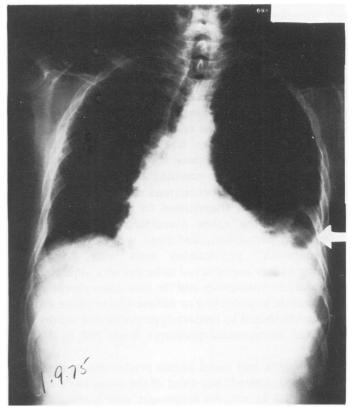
This postero-anterior chest x-ray of patient number 2 represents an example of a left hydropneumothorax seen after rupture of the esophagus.
